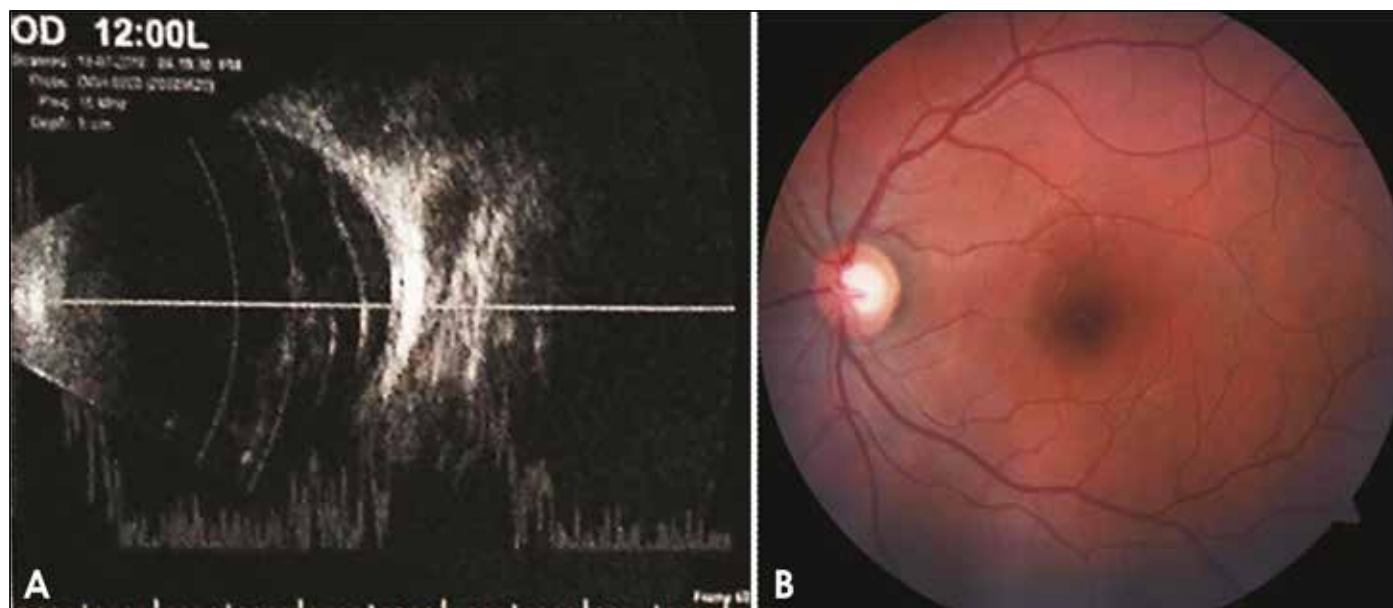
At presentation (A). Ultrasound B scan (OD) showing moderate vitreous haemorrhage with incomplete posterior vitreous detachment, (B). OS fundus with normal posterior pole.
